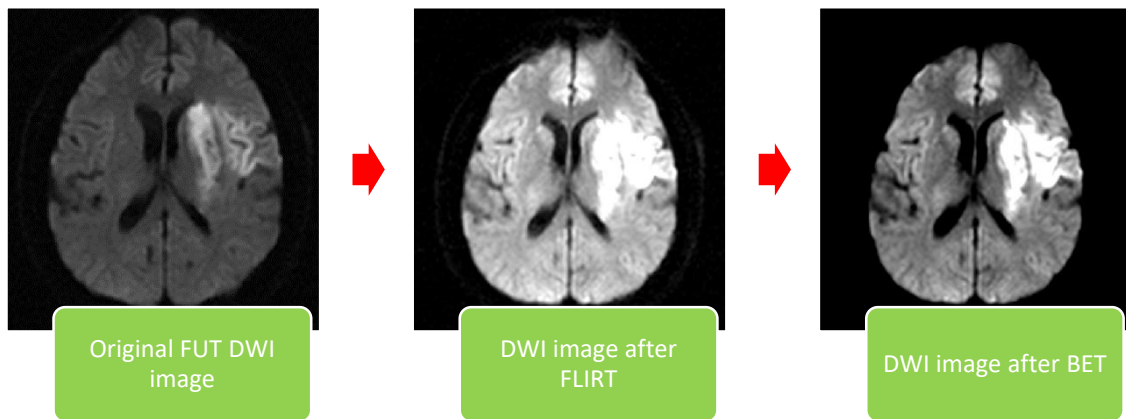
Steps involved in processing the FUT images with DWI images as examples.
